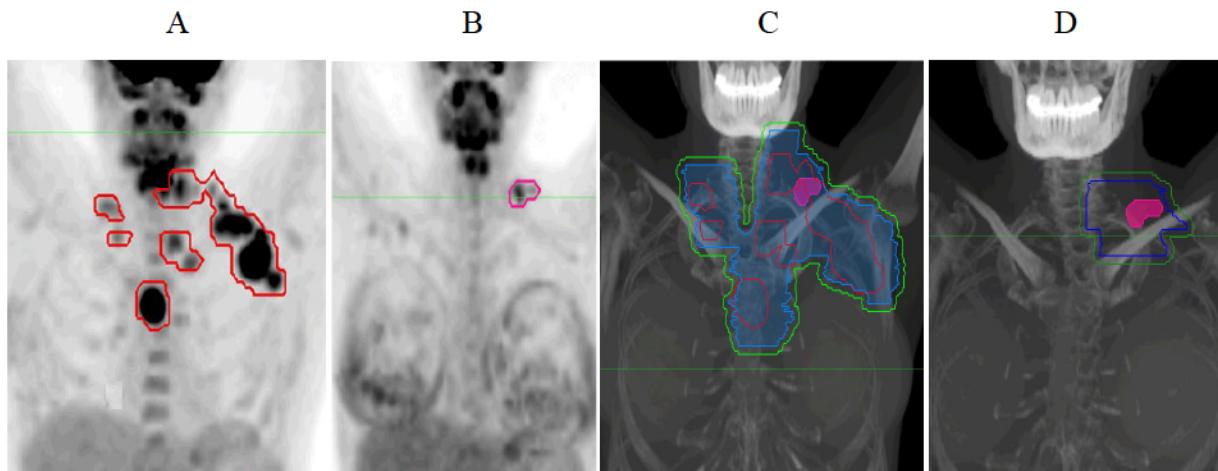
23yo presents with Stage IIA HL treated with ABVD x 3 with initial PET/CT (A). Relapses 6 months later with PET/CT (B). RT for patient enrolled in R1 study includes site of recurrence (pink) and sites involved within the prior 12 months (red) in the ISRT field with ITV (blue) and PTV (green) (C) being treated to 21 Gy. Reduced volume to just the site of recurrence to an additional dose of 9 Gy for a total dose of 30 Gy (D).
